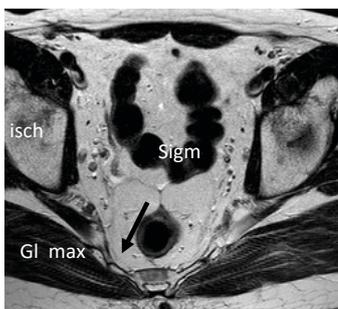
Axial T2-w MR image taken at the level of the ischiatic bone showing the typical appearance of the sacro recto-vesico genito pubic fascia (arrow). Gl max = gluteus maximus muscle; Isch = ischiatic bone; Sigm = sigmoid colon.
